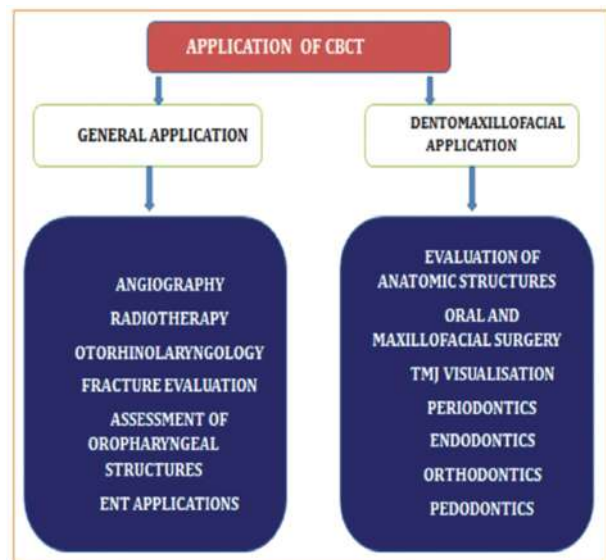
Application of CBCT
